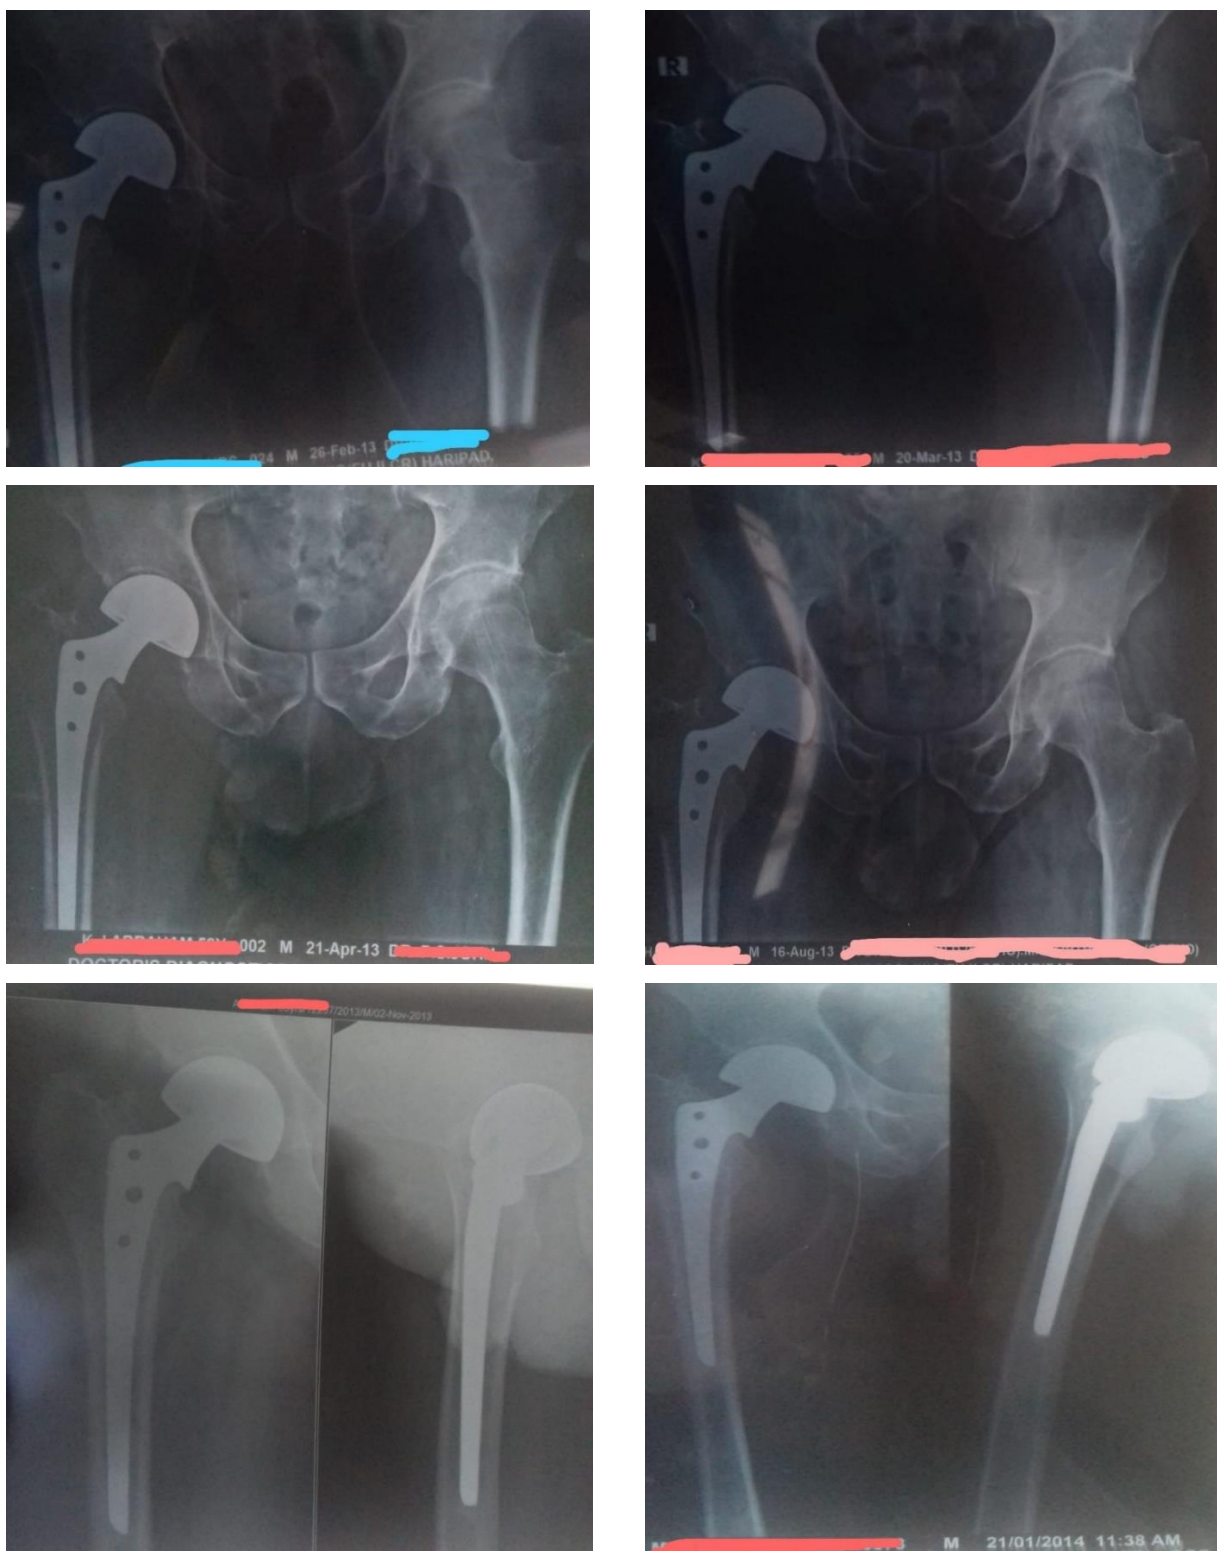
The X-Rays taken for observation during the various period of time during the treatment from 26 Feb 2013 to 02 Nov 2013 are given and can be compared to the 21 Jan 2014.
